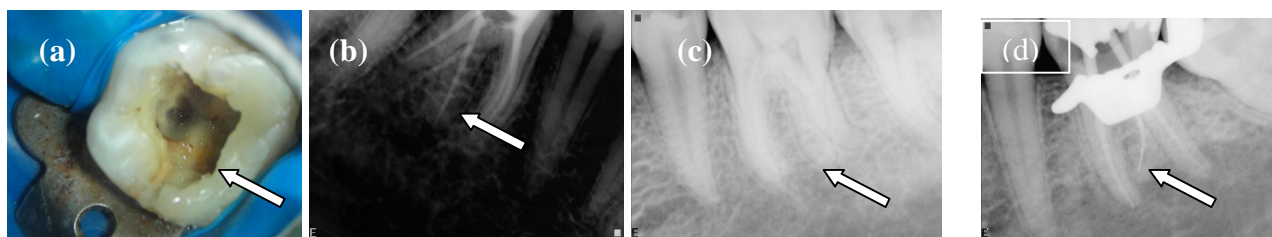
(a)- Access opening modified for RE in mandibular molar; (b-d)-Radiographs showing RE(arrow).
